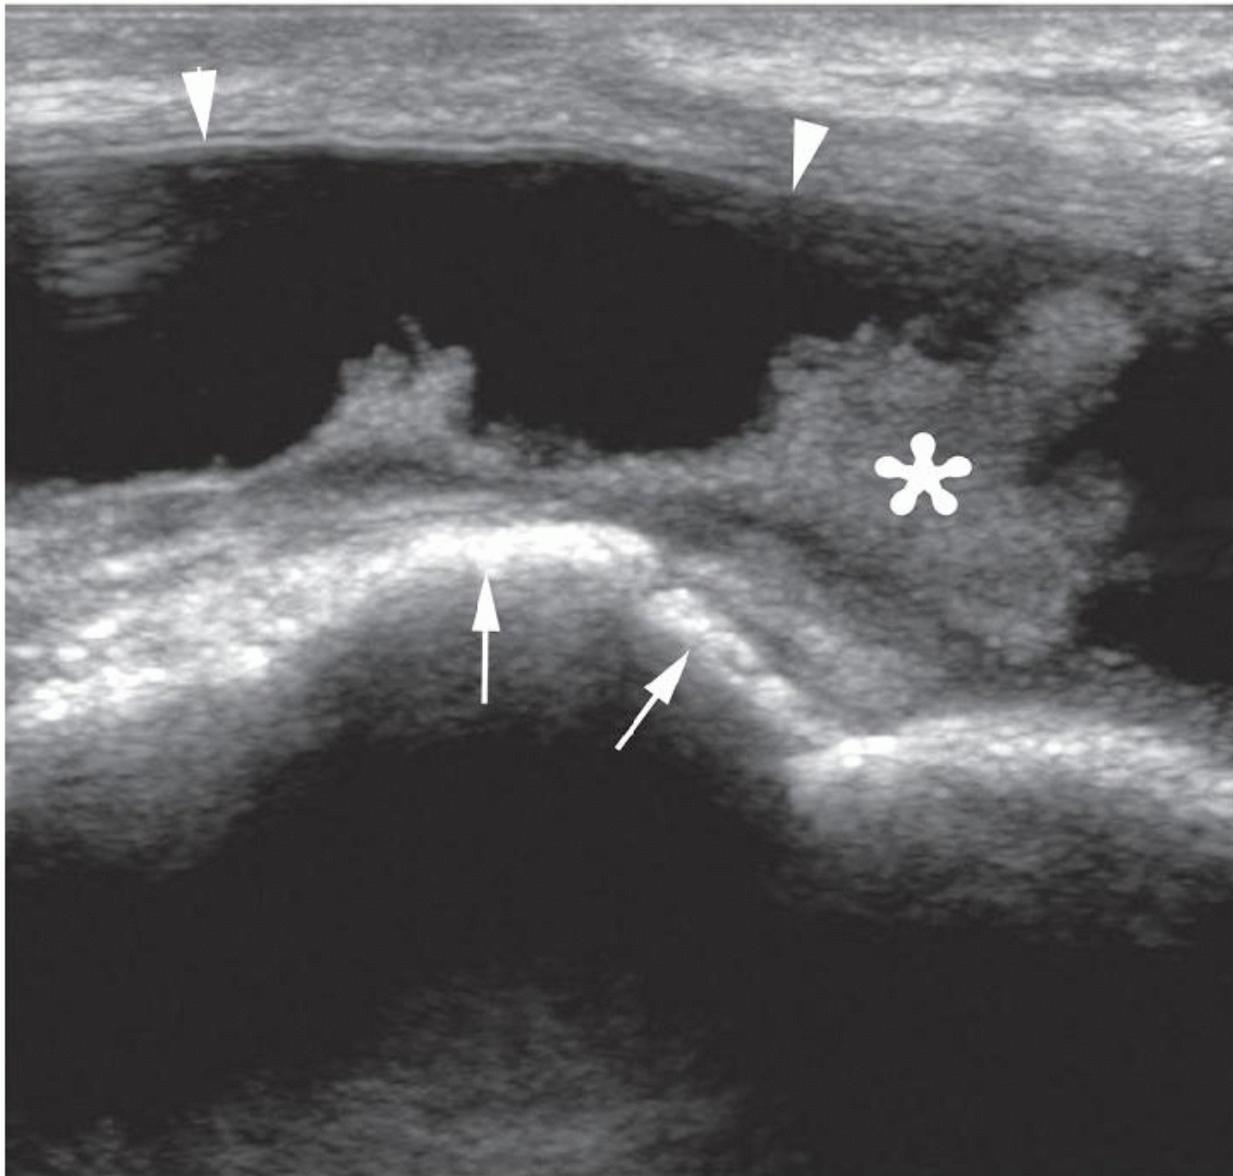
Bursa following THR. Longitudinal sonogram shows large anechoic bursa (arrowheads) with fronds of synovial thickening (asterisk) against hyperechoic prosthetic hip (arrows).
